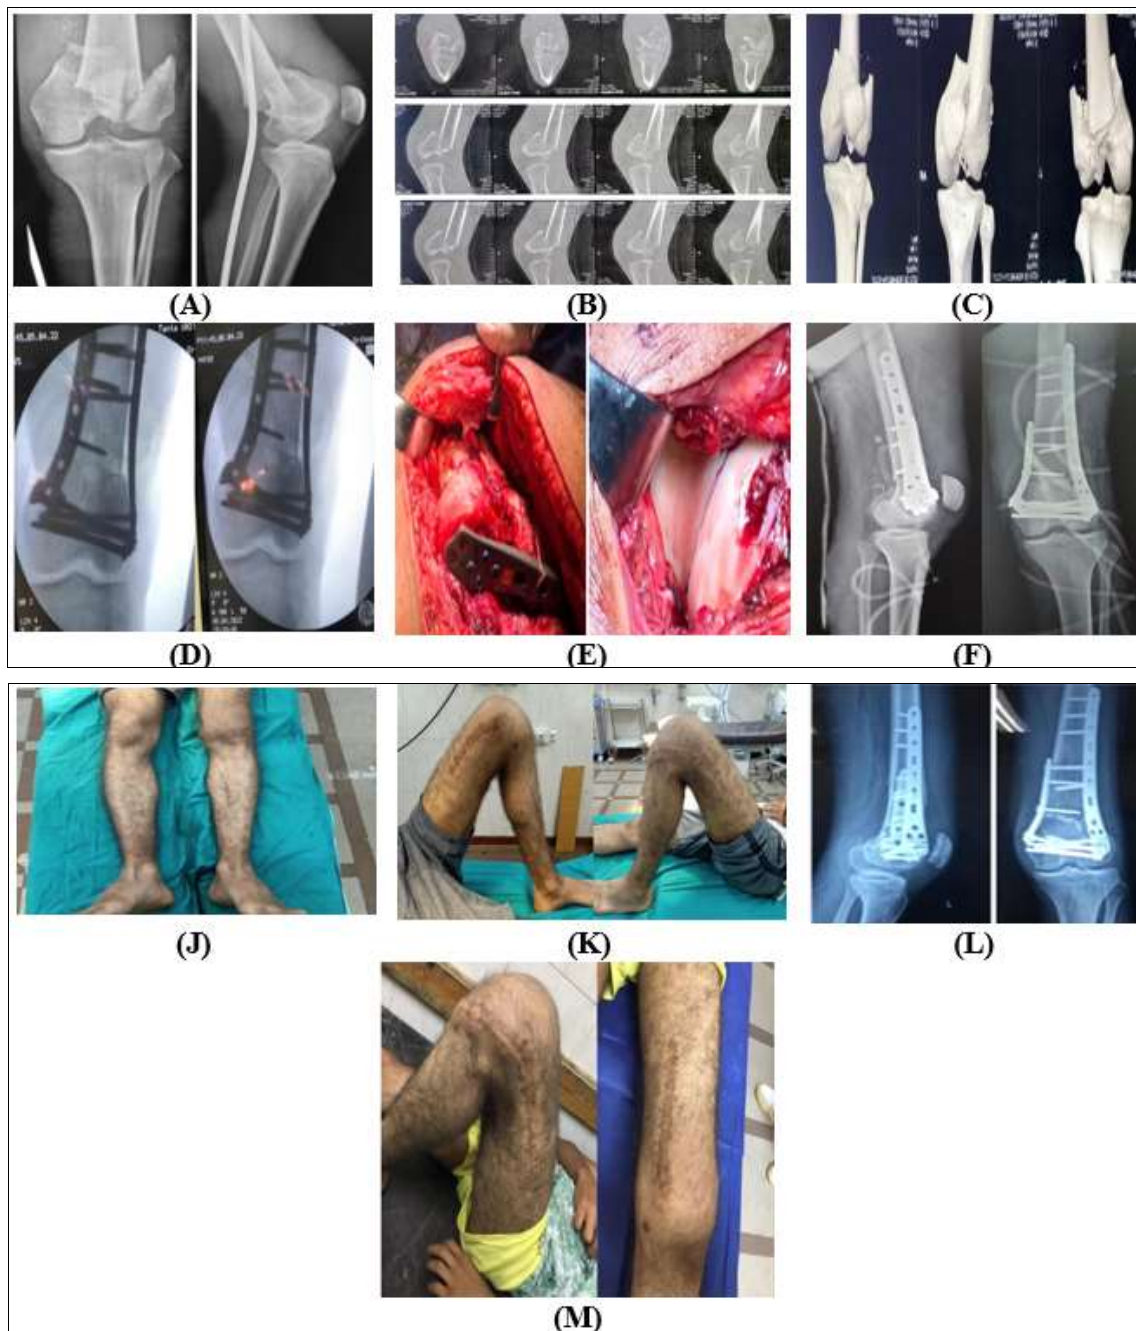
(A) X-ray on knee joint showing distal femur fracture with intercondylar extension, (B, C) Preoperative CT imaging of knee joint showing distal femur fracture Class (C2.2) according to the AO/OTA classification, (D) Intra-operative imaging on knee joint showing reduction of distal femur fracture and fixation by double plating, (E) Intra-operative picture showing reduction of distal femur fracture and fixation by double plating, (F) Immediate post-operative X-ray, Follow-up after (G, H) 3 months, (I, J, K) 6 months showing fracture union, (L, M) after 12 months
